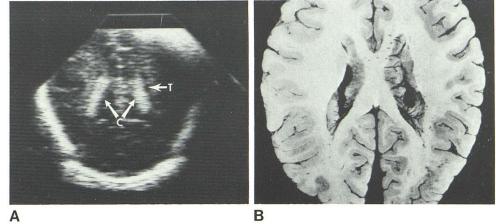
Sonogram (A) and corresponding normal anatomy (B). Choroid plexus (C) in trigone (T) region of lateral ventricle. (Reprinted from [7].)
